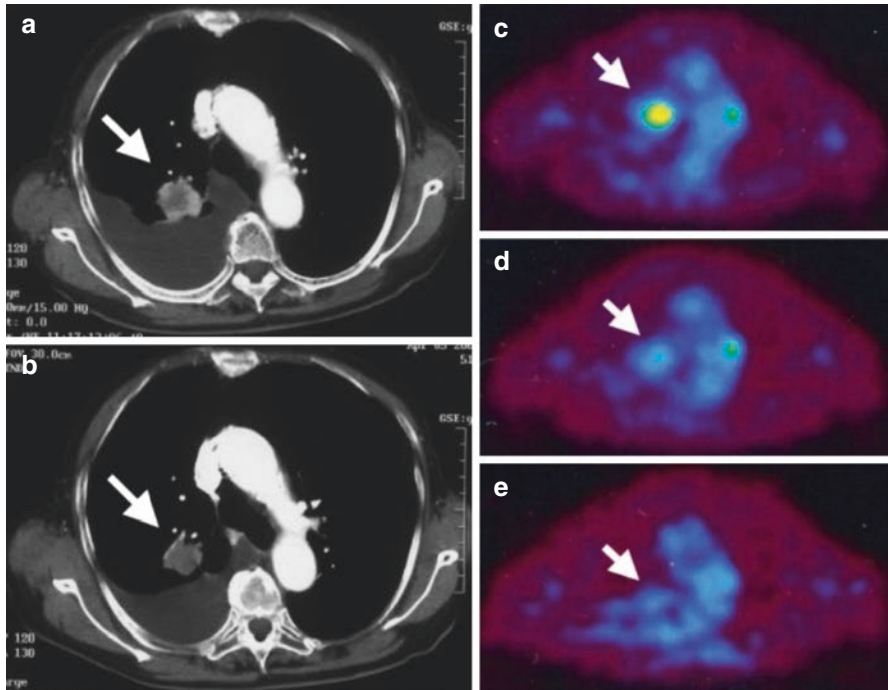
A representative case referred from reference number 11 (Sunaga, et al.). The tumor in the right lung field (a, white arrow) yielded no shrinkage on CT after 4 weeks (b) from the start of gefitinib. FDG-PET corresponding to this tumor on CT showed increased accumulation (c, white arrow) before the initiation of gefitinib, then, the accumulation decreased on 2 days (d) and 4 weeks from the start of gefitinib (e)
